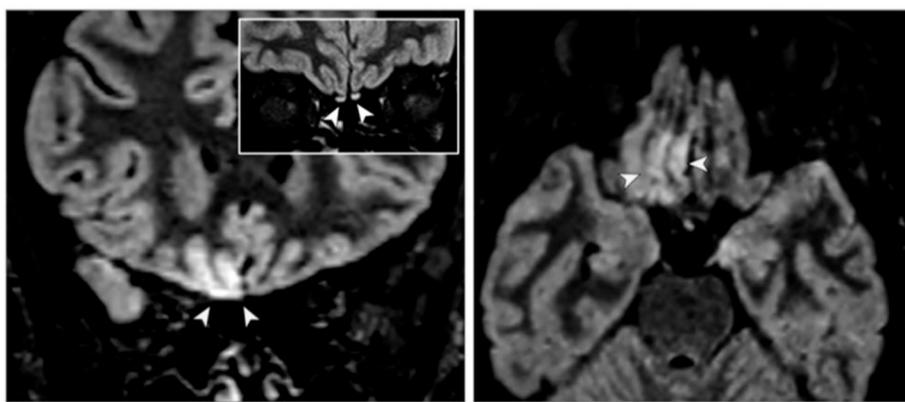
FLAIR image shows cortical hyperintensity in the right gyrus (yellow arrowheads) in both axial and coronal sections and subtle hyperintensity in the bilateral olfactory bulbs (white arrowheads) in the coronal section. From Politi SL et al. [209]
